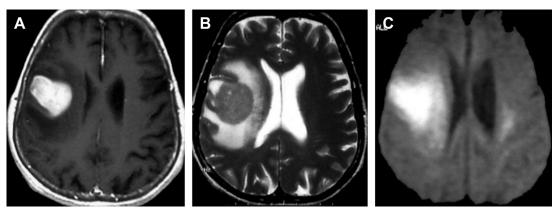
Supratentorial location, solitary mass. A 71-year-old woman with a well-circumscribed lesion in the right frontal lobe with solid enhancement (A, axial T1 with contrast), isointense to gray matter on T2 (B, axial T2), and bright on diffusion-weighted imaging (DWI) (C) indicating restricted diffusion. Pathology was consistent with lymphoma.
